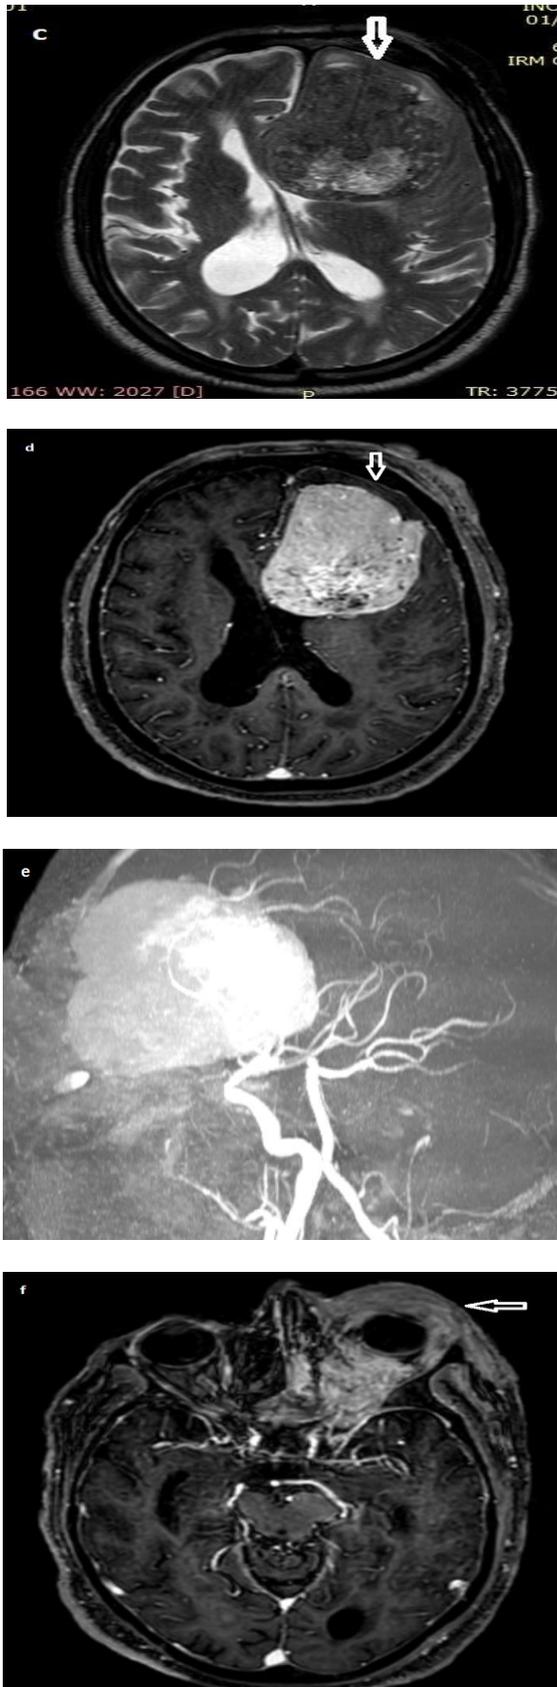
Brain MRI in axial T2-weighted sequences (c), axial T1 WS after gadolinium injection (d, f) and 3D TOF, showing an extra axial left frontal tumor process in heterogeneous T2 signal with signal-void vessels (arrow, c), enhanced intensively and heterogeneously after gadolinium injection (arrow, d), associated with left palpebral orbito hemangioma enhancing intensively after injection (arrow, f).
